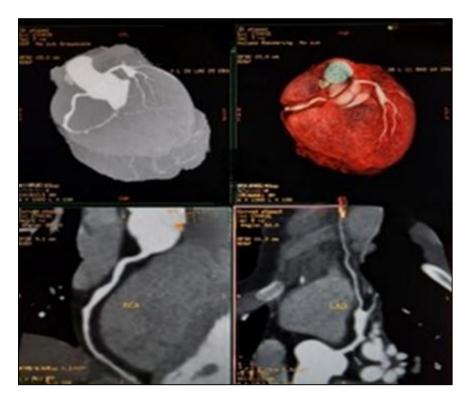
CT Angio refformatations ,MIP,VR
